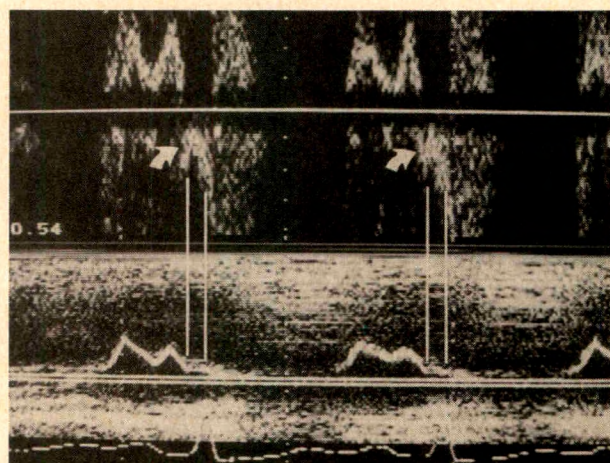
Pulsed-wave Doppler echocardiographic detection of mitral regurgitation (white arrows) coinciding with the B-bump formation of the mitral valve on the M-mode echocardiogram. Backward flows (white arrows) are shown to coincide with the mitral valve B bump.
